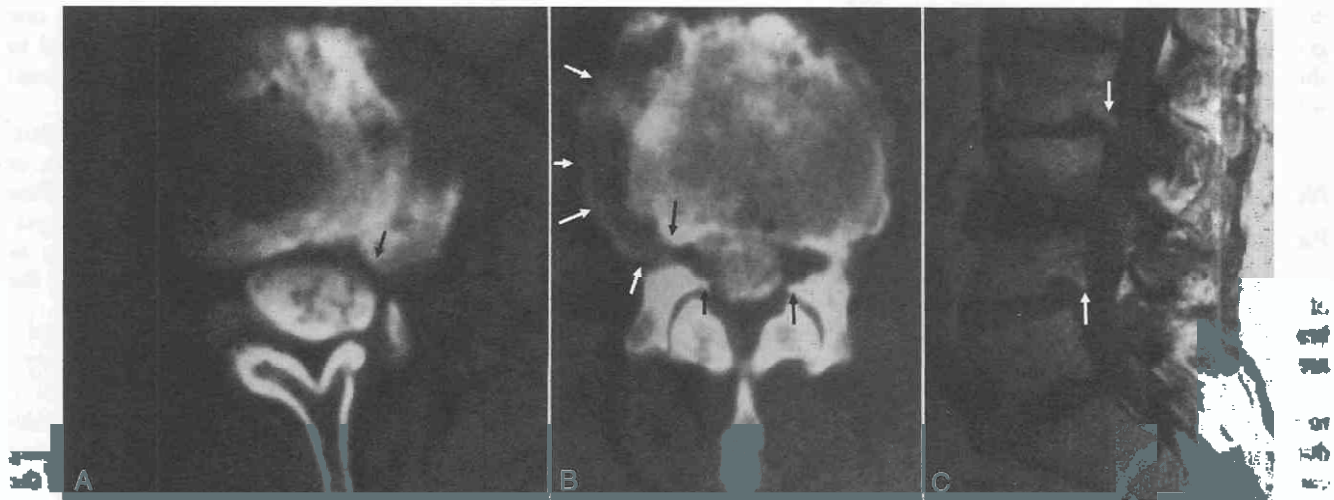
Osteophytes. *A* and *B*, Postmyelogram CT scans show osteophytes (arrows) encroaching on the canal and foramina. *C*, Sagittal T1-weighted MR image shows osteophytes (arrows) encroaching on the canal.
